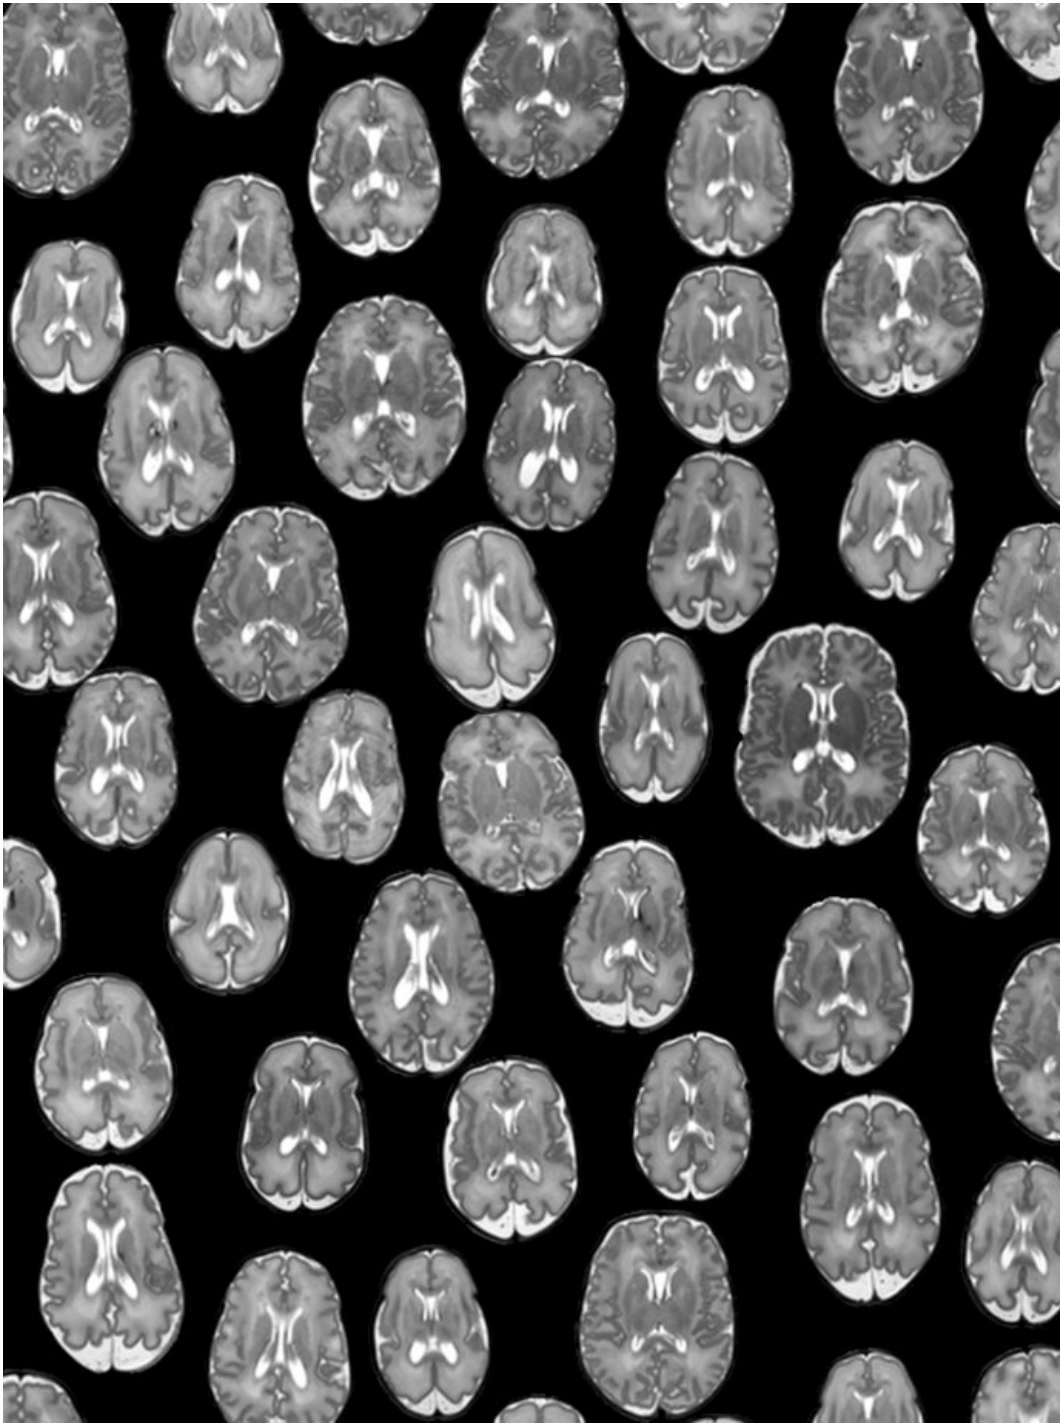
Preterm MRI dataset examples. Axial slices of the preterm brain are shown for a random subset of the 196 subjects selected for comparison with the fetal dataset (postmenstrual age range: 26.57 – 37.14).
